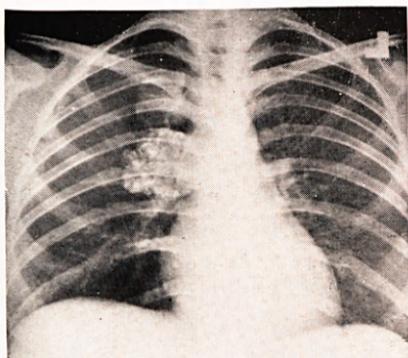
Straight X-ray of chest, August, 1952, showing masses in R. hilum, the lower one calcified.
